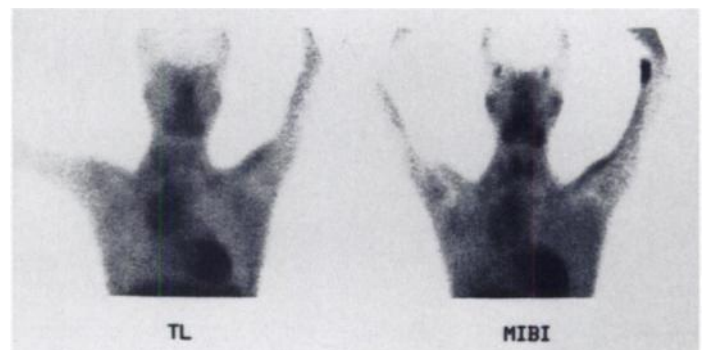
A 12-yr-old girl (Patient 8) with HD who had right cervical and mediastinal masses visualized by ²⁰¹Tl (left) and ^{99m}Tc-sestamibi scintigraphy (right). Visual grading scores and T/B ratios for cervical and mediastinal masses were 3+, 1.36 and 4+, 1.90, respectively, in the ²⁰¹Tl study. They were 3+, 1.30 and 4+, 1.50, respectively, in the ^{99m}Tc-sestamibi study. The patient had complete response to subsequent chemotherapy.
